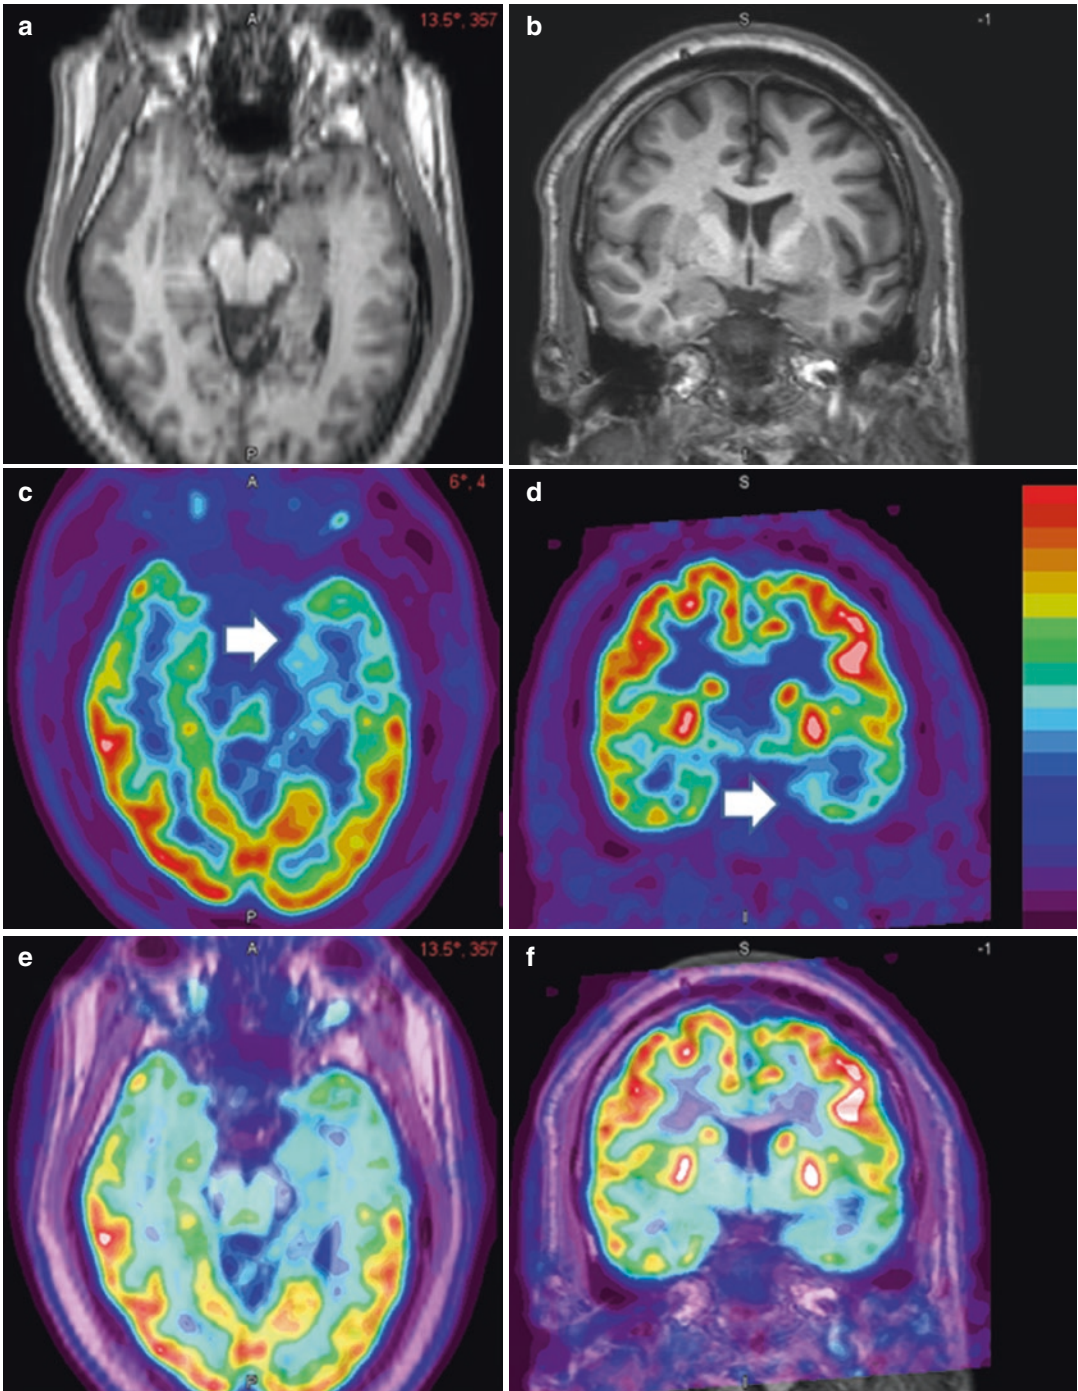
Brain $[^{18}\text{F}]\text{FDG}$ -PET in a patient with medically refractory epilepsy performed between seizures (interictal study). T1-weighted axial (a) and coronal (b) MR images, axial (c) and coronal (d) $[^{18}\text{F}]\text{FDG}$ -PET, and fused PET/MR images (e, f) demonstrate decreased $[^{18}\text{F}]\text{FDG}$ uptake
